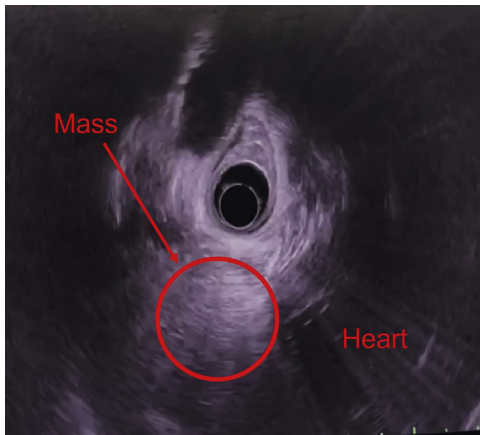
Radial ultrasound view of the intraventricular mass.
